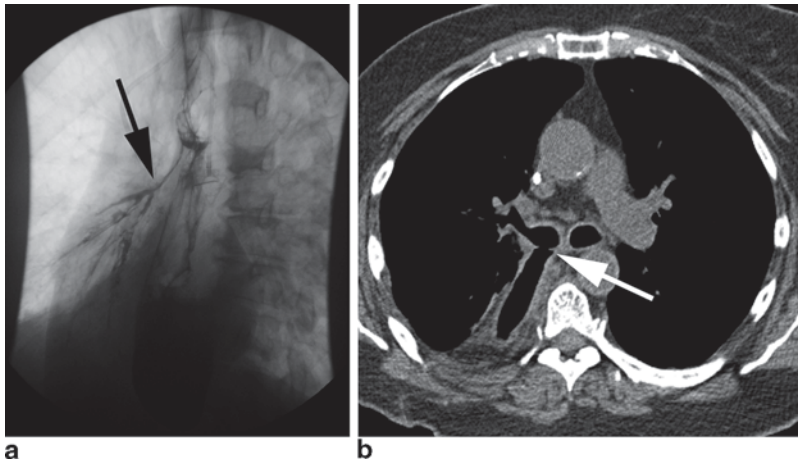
Chronic leaks can fistulize to adjacent organs including the tracheobronchial tree as seen here on esophagram (black arrow) (a) and CT scan (white arrow) (b)
